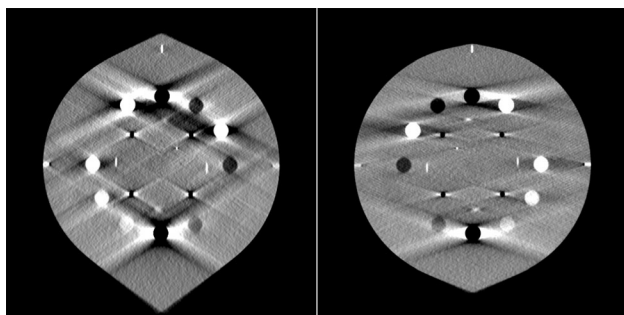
CT Number slice from the Catphan for the 120 arc length (left) and 150 degree arc length (Right)
